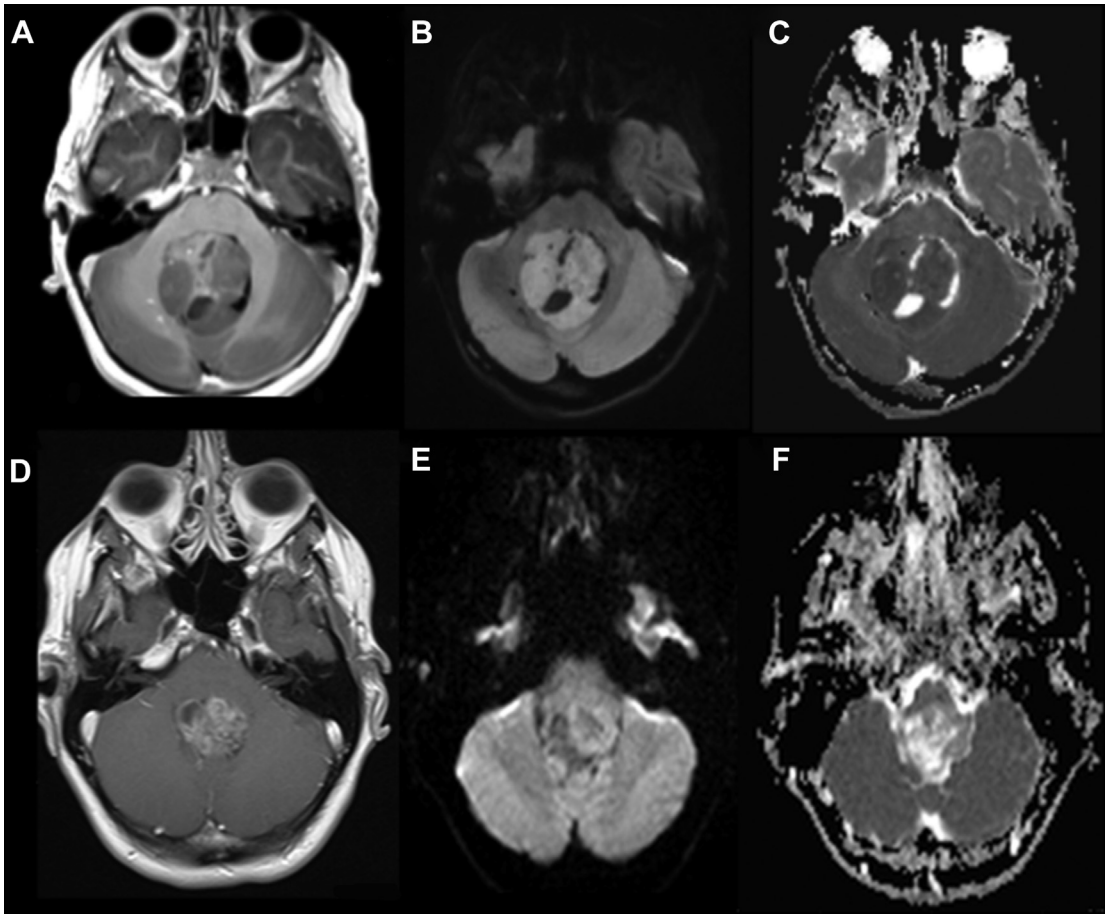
Two different fourth ventricle tumors demonstrating heterogeneous enhancement on T1 postcontrast images. Medulloblastoma (A) demonstrating high signal intensity on DWI (B) and lower ADC than adjacent cerebellum (C). Ependymoma (D) demonstrating intermediate signal on DWI (E) but high ADC compared with the cerebellum (F).
